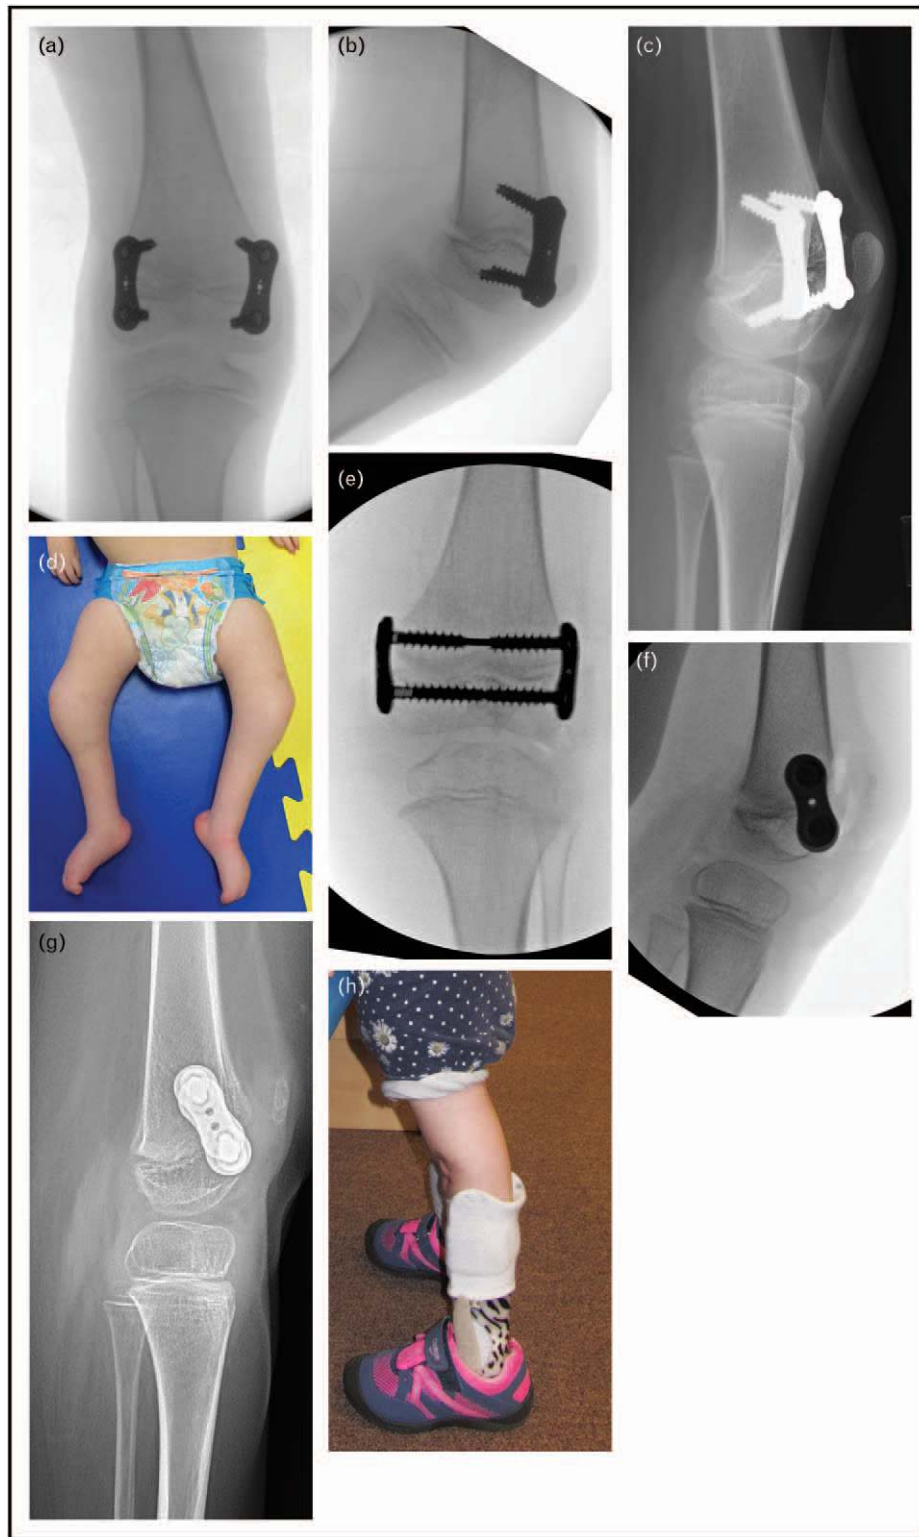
Anterior distal femoral hemiepiphysiodesis: (a) immediate postoperative AP radiograph of the right knee of an 8-year-old boy with arthrogryposis, after placement of medial and lateral physal tethering plates for a 20° knee flexion contracture; (b) immediate postoperative lateral radiograph of right knee; (c) lateral radiograph of right knee 12 months later, demonstrating divergence of the fixation screws, and correction of the flexion contracture. (d) Clinical photograph of a 3-year-old girl with arthrogryposis, demonstrating her 45° and 25° left knee flexion contractures; (e) immediate postoperative AP left knee radiograph following bilateral anterior distal femoral hemiepiphysiodesis with the physal bridge technique at 6 years old; (f) immediate postoperative lateral left knee radiograph; (g) follow-up lateral radiograph of left knee 5 months postoperative, demonstrating significant physal obliquity; (h) clinical photograph demonstrating a fully extended knee.
